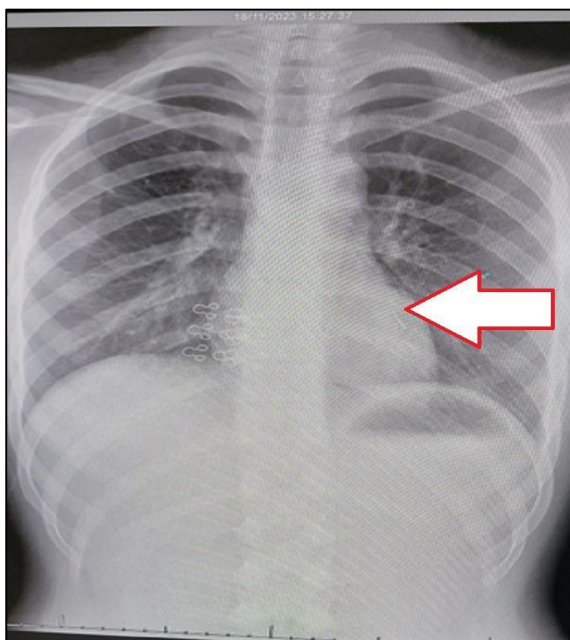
A simple chest x-ray displayed a needle in the chest.
